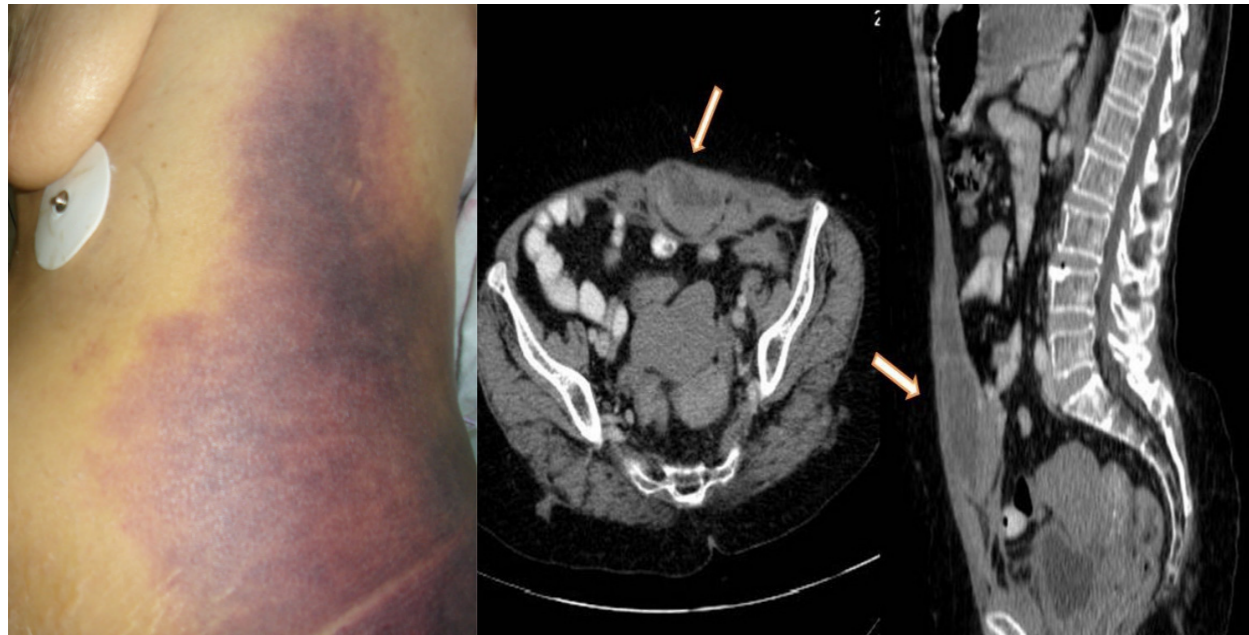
1; The patient with ecchymosis in the abdominal wall and left flank, 2; Computed tomography scan of the patient showing the hematoma limited in the left rectus abdominis sheath
